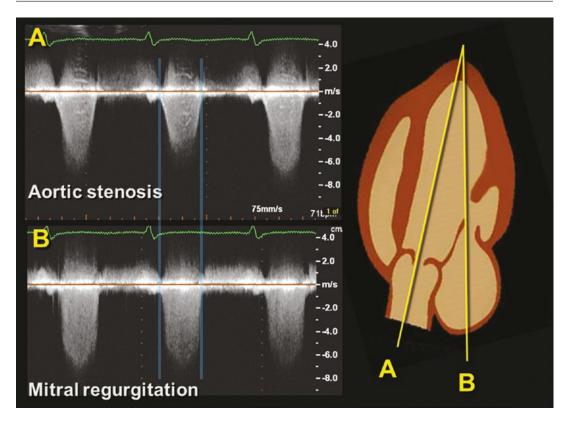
Continuous wave Doppler recordings from a patient with aortic stenosis (top panel) and mitral regurgitation (bottom panel). The light blue areas represent the periods of isovolumic relaxation and isovolumic contraction
